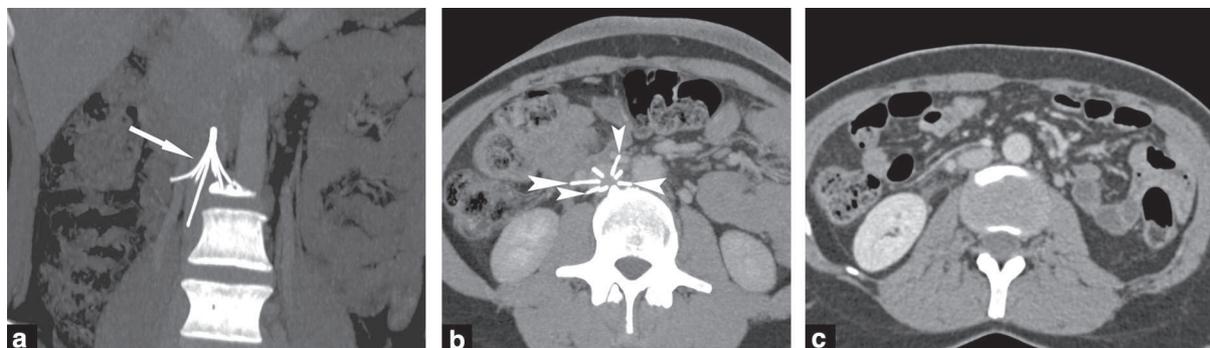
Computed tomography (CT) images in a 26-year-old woman before and after inferior vena cava (IVC) filter removal. a. Before IVC filter removal, CT image in the coronal plane using a maximum intensity projection reconstruction shows IVC filter (arrow). b. Before IVC filter removal, CT image in the transverse plane shows IVC filter and filter legs (arrowheads) protruding outside the IVC wall. c. After IVC filter removal, control CT image in the transverse plane shows no active bleeding or hematoma in the retroperitoneum.
